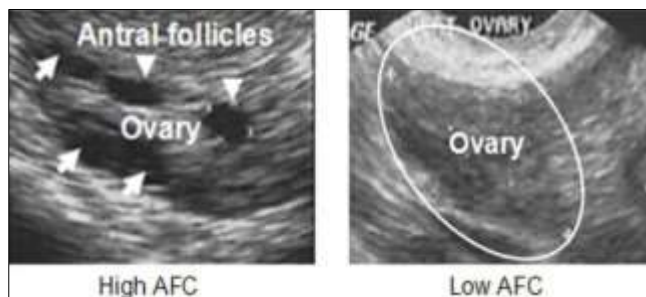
Transvaginal Ultrasound Image Showing Ovarian Reserve. This image shows a healthy ovary with a visible count of antral follicles, indicating a good ovarian reserve. The image would highlight multiple small follicles, which are crucial for ovulation.
